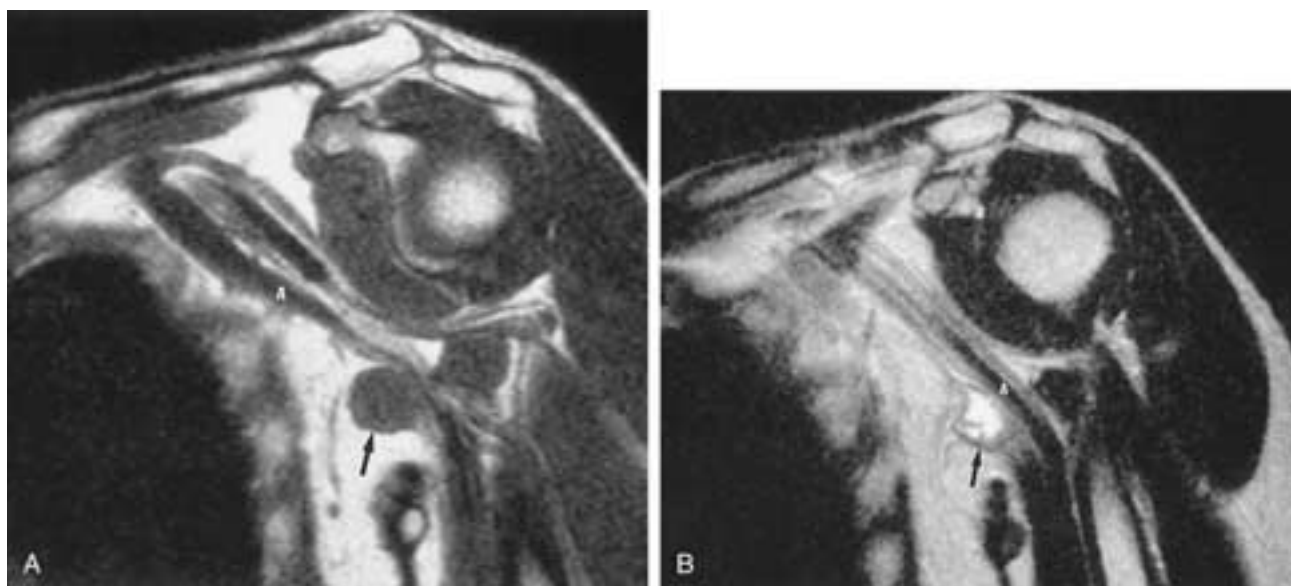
Neural tumor. Coronal T1-weighted (A) and T2-weighted (B) MR images through the region of the axilla show a mass (arrow in B) arising from one of the nerves medial to the axillary artery (A). This mass has an intermediate signal on T1-weighted images and becomes hyperintense on T2-weighted sequences.
